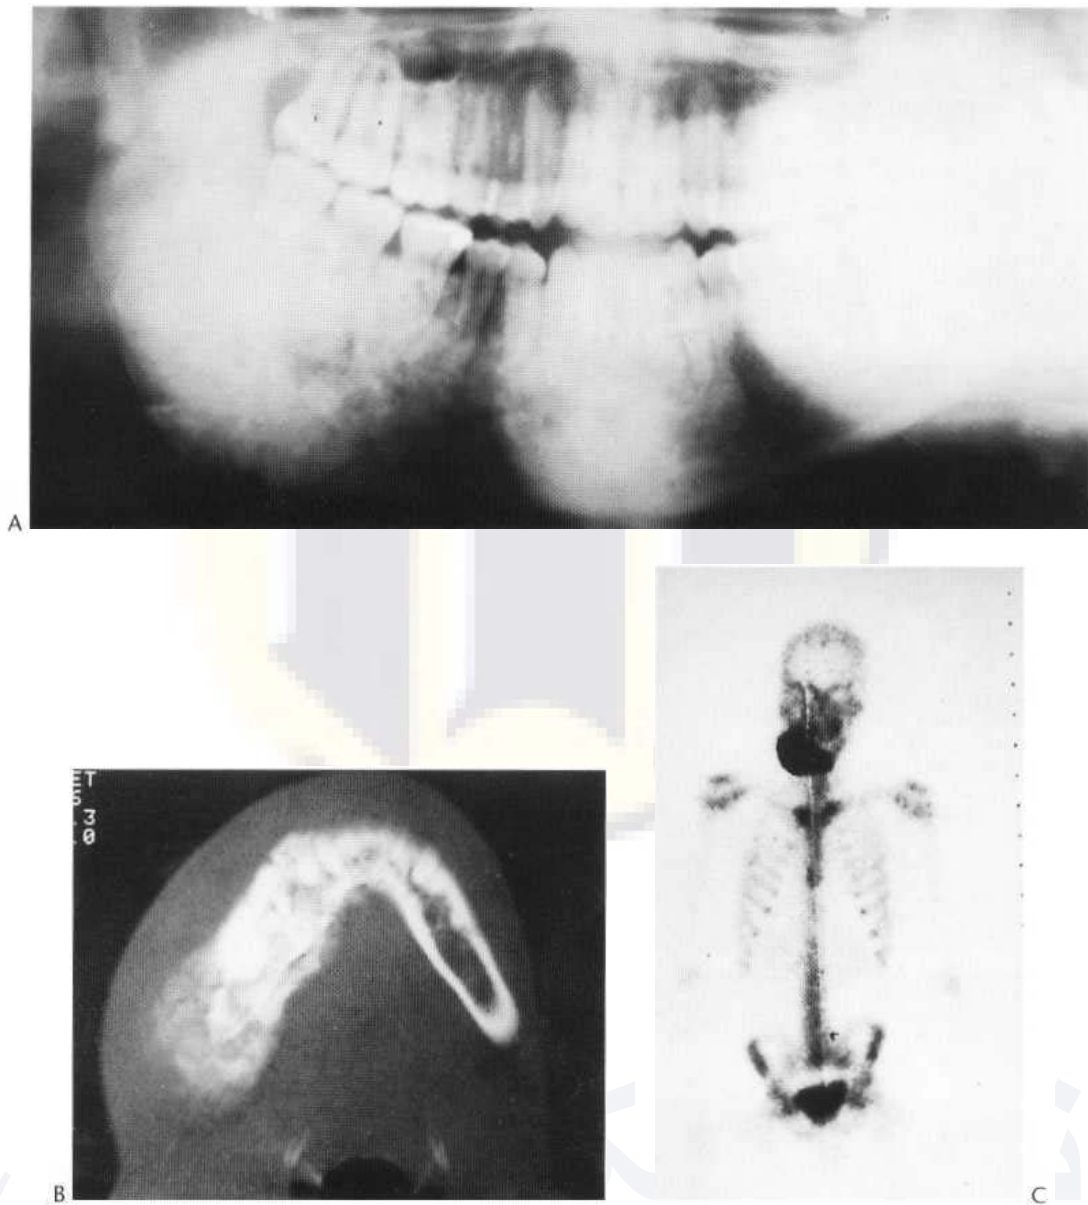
Osteogenic sarcoma in a 26-year-old man. (A) Panoramic view shows a large bone-forming tumour affecting the right hemimandible and crossing the midline. (B) CT scan confirms the extent of involvement. (C) Radioisotope bone scan also delineates the affected area.
